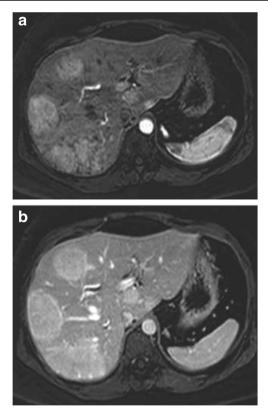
Hepatic adenomatosis in an asymptomatic 39-year-old female. Axial postgadolinium MRI demonstrated the hypervascular nature of all detected lesions with intense enhancement in the arterial phase (a) that persisted in the delayed phase (b). Images taken from De Kock I et al. 2014^{35}
